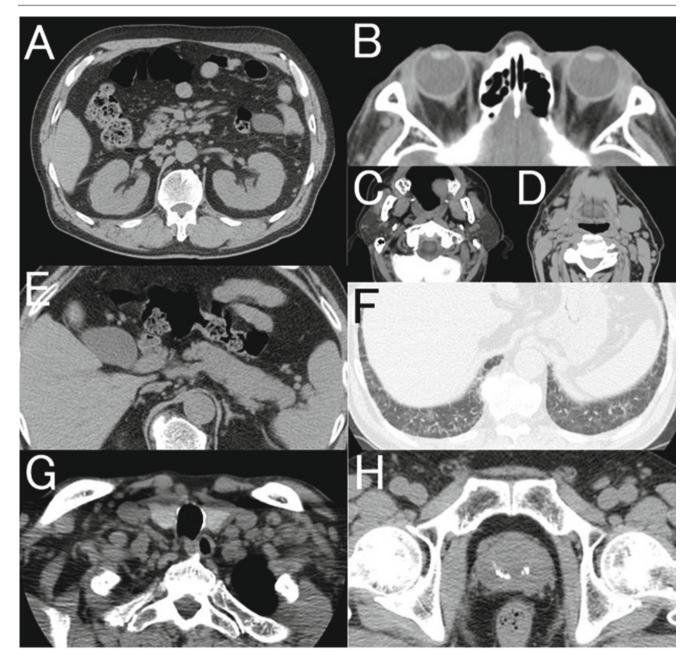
Plain computed tomography (CT) findings of the present case. Diffuse bilateral renal swelling was observed before therapy (a). Bilateral lacrimal and parotid glands and left submandibular gland
